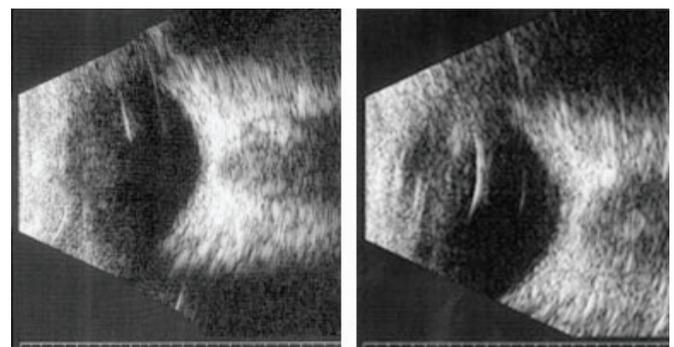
B-scan ultrasound of Case 2. Decreased vitreous cavity length causing the decrease in total axial length of both eyes.
